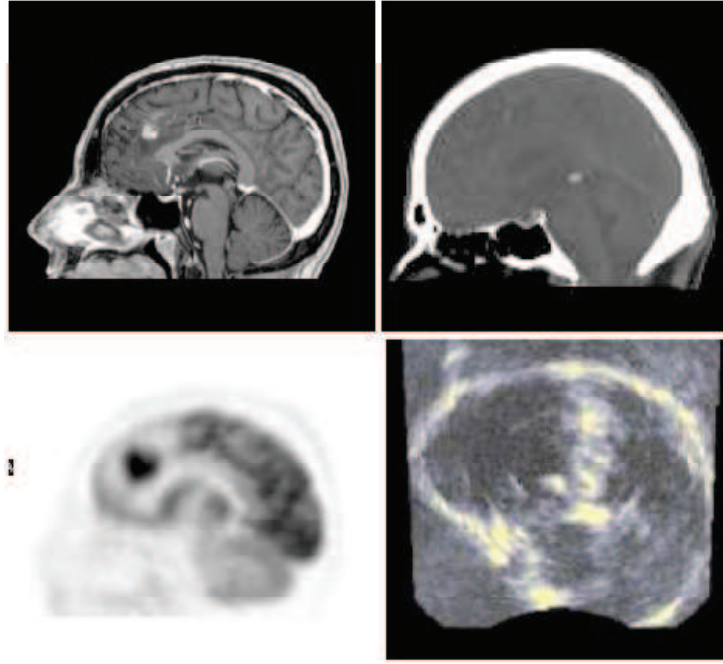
Sagittal slices of the brain by different imaging modalities. From top-left to down-right: Magnetic Resonance Imaging, Computed Tomography, Positron Emission Tomography and Ultrasound [29].
